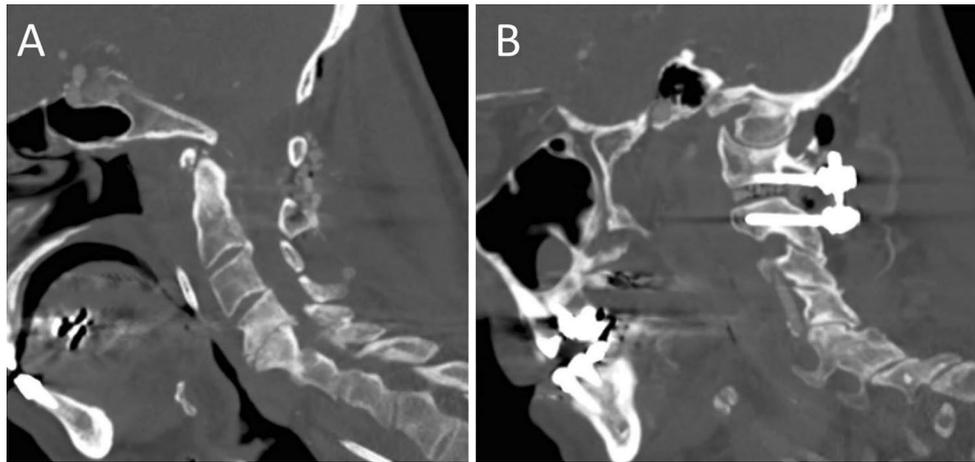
Post-operative CT cervical spine, mid-sagittal (a) and lateral sagittal (b). There is reduction in the posterior atlantoaxial dislocation, with lateral mass screws to C1 and pedicle screws to C2. There is autologous bone grafting to the interfacet space
